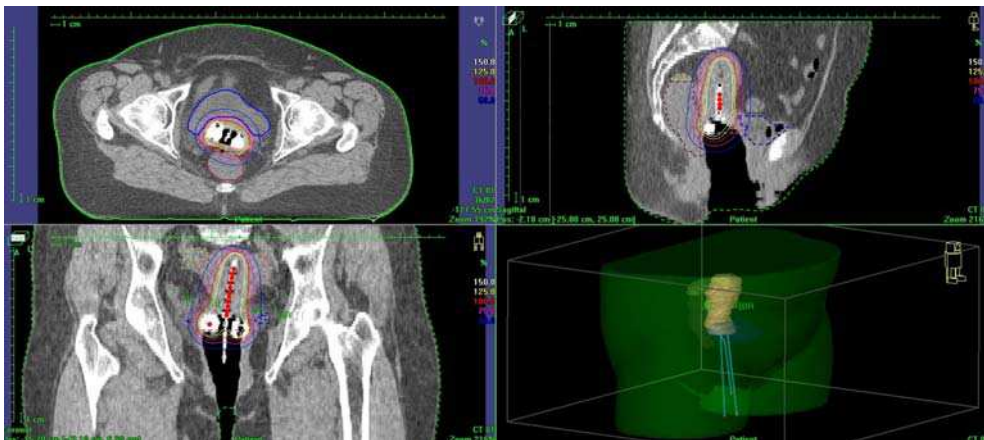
Cervical cancer - reconstruction of plastic applicator in a 3D CT study. Plastic catheters - intrauterine tube and ovoids are inserted into vaginal vaults and uterus. (a) Para-transverse image at the level of the ovoids, (b) Para-coronal image and (c) Para-sagittal image with a reconstructed tube and ovoids. On (d) 3D-visualisation of application is presented.
